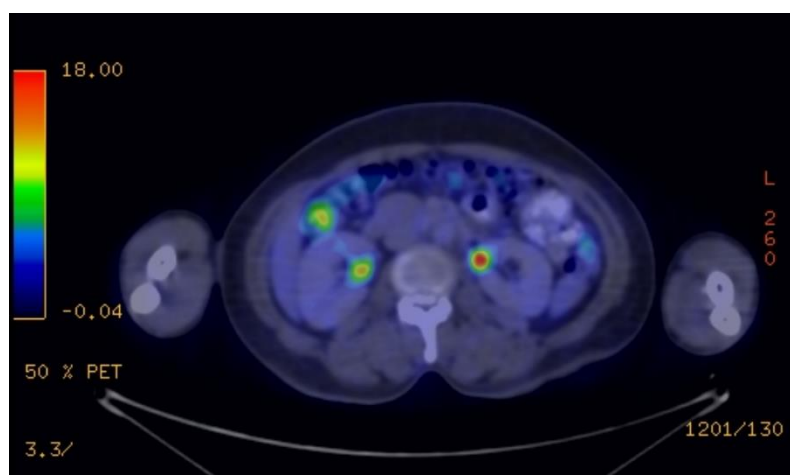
PET/CT scan showing the focal area of increased metabolic activity in the bilateral
